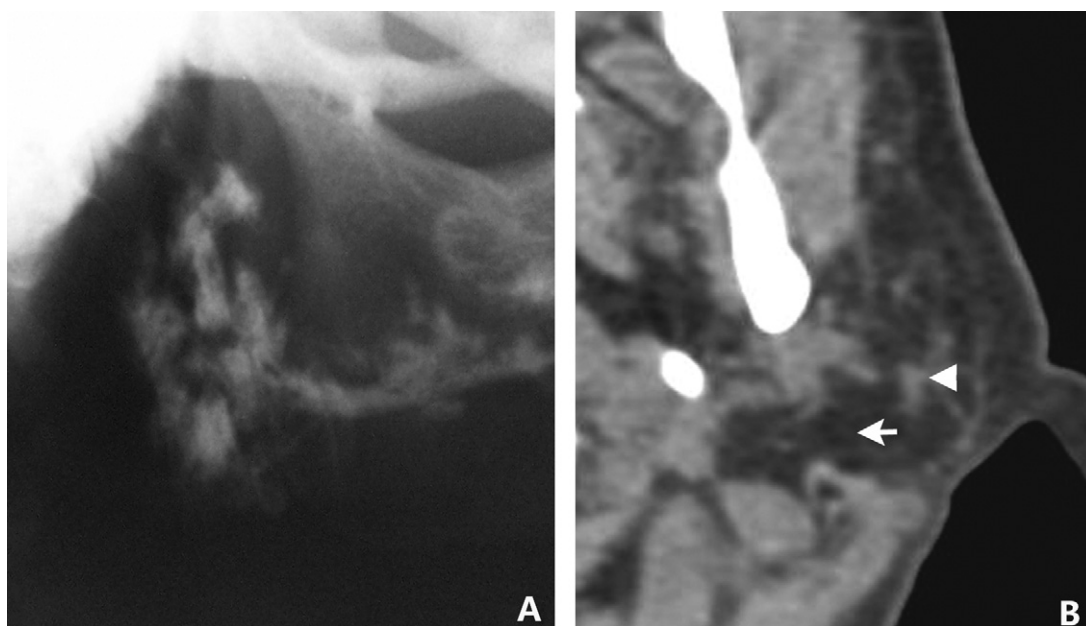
Sialogram and CT in stage 4 of SS. The sialogram of a stage 4 patient (66-year-old, female) shows destruction and atrophy of the gland parenchyma (A) and marked dilatation of the main duct with an irregular diameter (A). In the same patient, more than 50% of the total parotid gland area is replaced by adipose tissue (B, white arrow) and atrophy of the parenchyma of the parotid gland (white arrow head) could be observed.
